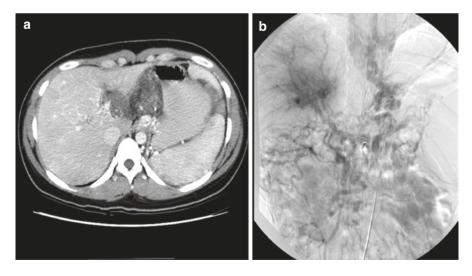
Radiologic imaging of the abdomen and portomesenteric venous system; (a) computed tomography (CT) with no radiologic features of hepatic cirrhosis and preserved liver volume. The observed portal vein thrombosis dictated the need for visceral angiography. (b) The venous phase of selective superior mesenteric arteriography demonstrating diffuse portomesenteric venous thrombosis with development of extensive abdominal collaterals. Note the presence of large gastroesophageal variceal collaterals with some hepatopedal flow
